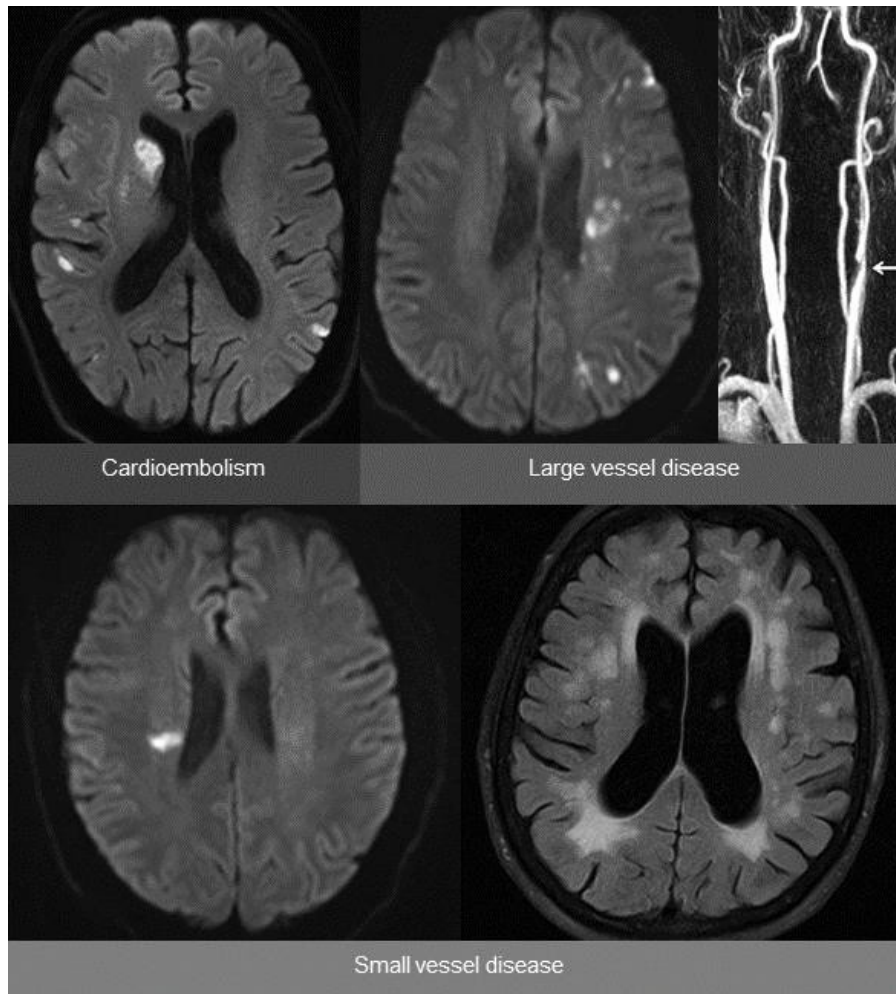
Typical ischemic stroke patterns on brain magnetic resonance imaging: Cardioembolism often leads to infarcts in multiple vascular territories while large vessel disease-associated stroke typically affects the borderzone areas of one brain-supplying vessel. Small subcortical infarcts and white matter hyperintensities are classical features of cerebral small vessel disease (*own figure*).
